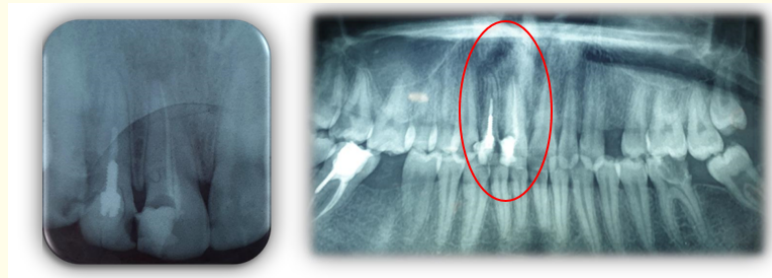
Pre-operative panoramic and Retro alveolar radiograph show the presence of screw post in 12, incomplete endodontic treatment in 12 and 11.
